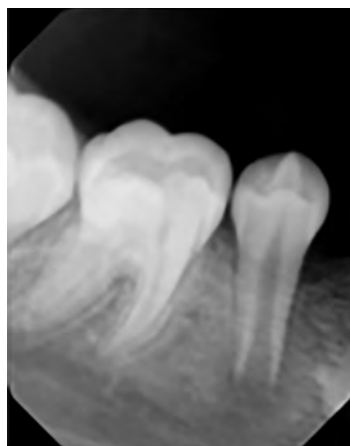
Periapical radiograph obtained in clinic following the ER visit.
